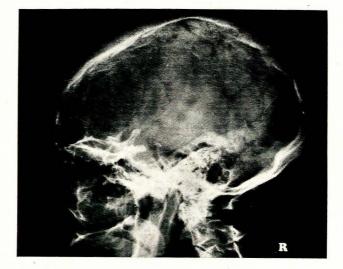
Lateral radiograph of the skull, demonstrating enlargement of the pituitary fossa with a double floor, undercutting of the anterior clinoid processes, and thinning of the dorsum sellae.
